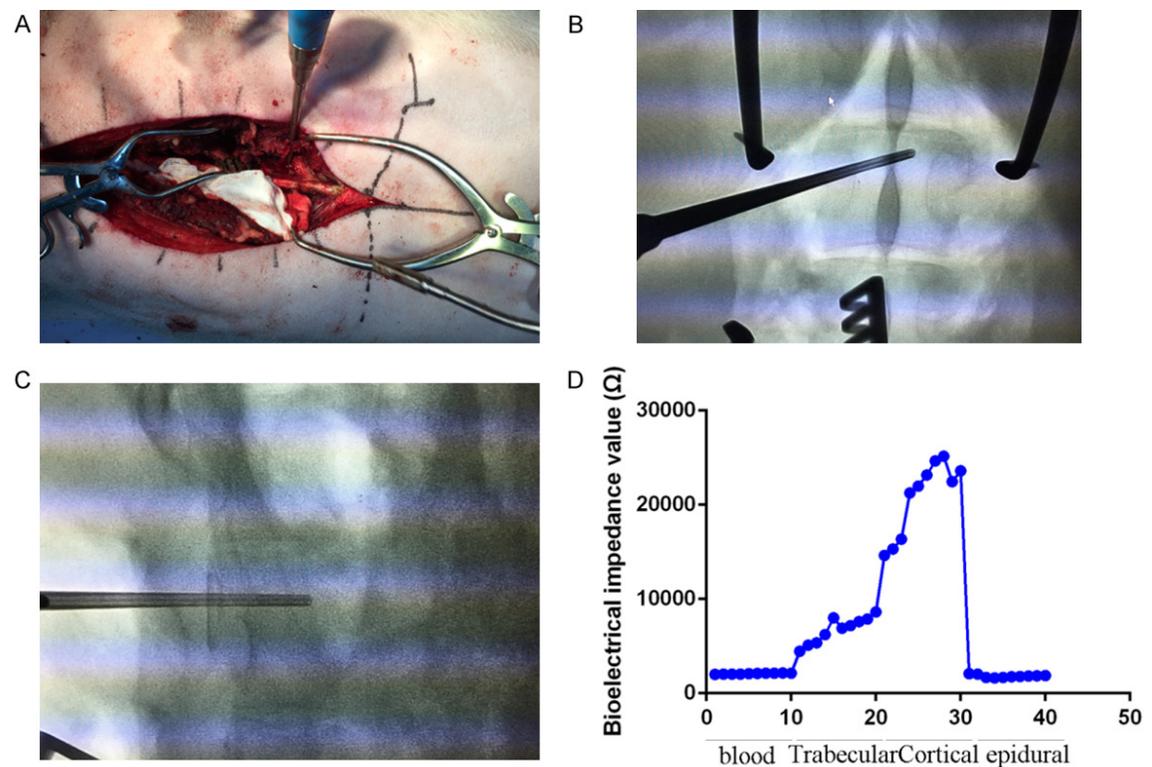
A pedicle screw canal that passed through the spinal canal to mimic pedicle screw misplacement. A. The insertion of pedicle probe during the operation is shown. B, C. The creation of an incorrect pedicle screw path was confirmed by anteroposterior and lateral radiographs. D. The changes in bioelectrical impedance value of the last procedure suggested that the probe had passed through four tissues, namely blood, trabecular bone, dura mater and cortical bone. The x-axis indicated time.
